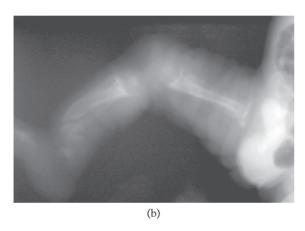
X-ray showing severe skeletal changes including diffuse subperiostal demineralization of long bones, bowed legs and irregular demineralization of metaphyses of long tubular bones (dysostosis multiplex resembling the radiological features of rickets).
